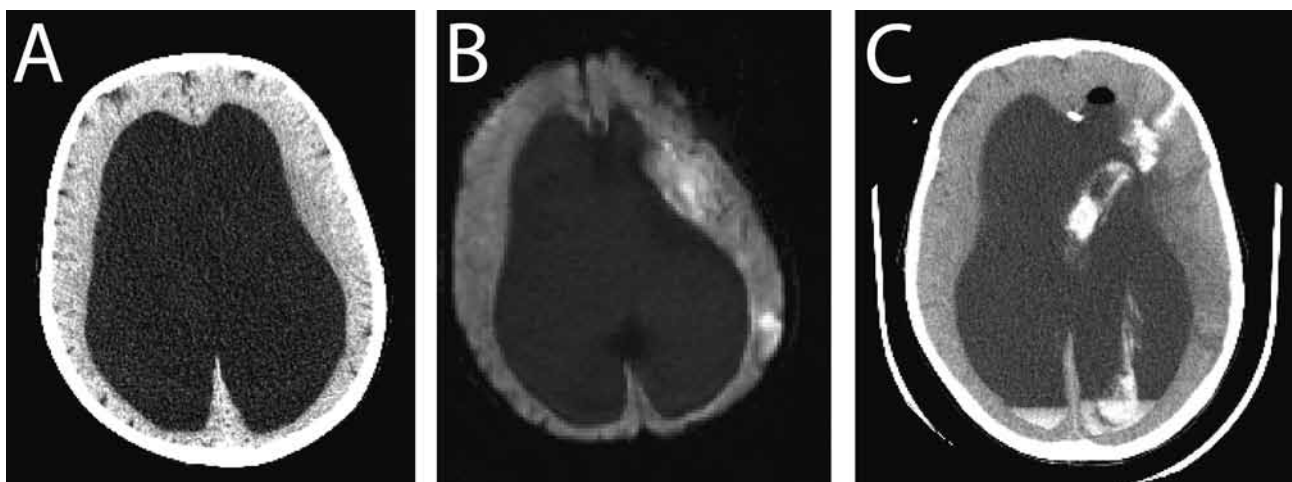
A) Head CT revealing giant hydrocephalus of the lateral ventricles. B) Brain MRI DWI sequence confirming acute to subacute infarcts of the left middle cerebral artery. C) Head CT showing intraventricular catheter plus some intraventricular hemorrhage.
